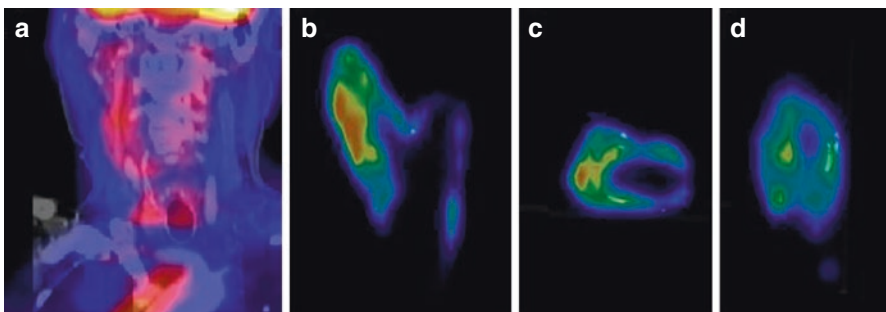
Clinical fused PET-CT image from a patient showing FDG uptake in the affected right carotid artery (a). Coronal (b), transverse (c), and sagittal plane (d) of corresponding μ PET images in the same patient showing also patchy FDG uptake and calcified areas (white depositions) (Masteling et al. 2011)
